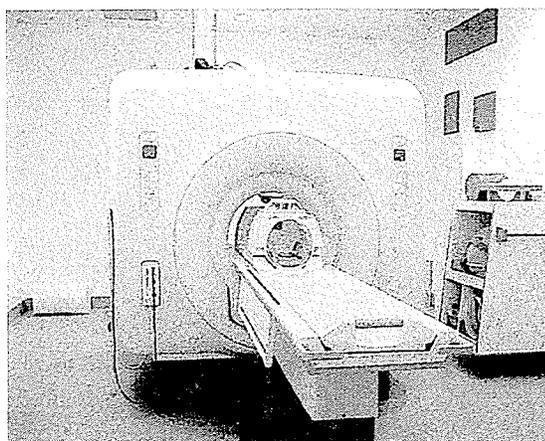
Magnetic Resonance Imaging System at Health Sciences Centre, Winnipeg, Manitoba.
